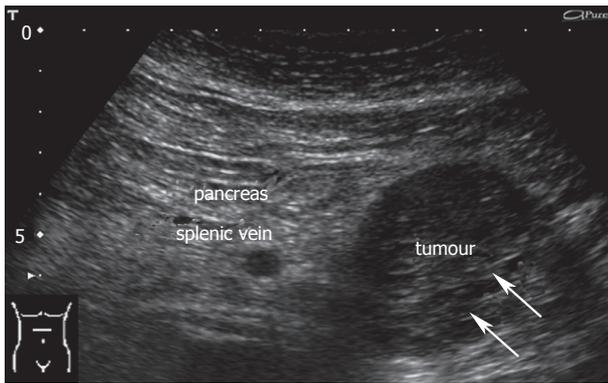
Cystadenoma at conventional and echo-enhanced ultrasound. A: A tumour at the pancreatic tail (5 cm in diameter) with small cystic areas (small arrows) and thin fibrotic strands; B: Highly vascularized tumour arteries (large arrows) along the fibrotic strands (maximum of contrastation 15 s after injection of the echo-enhancer).
